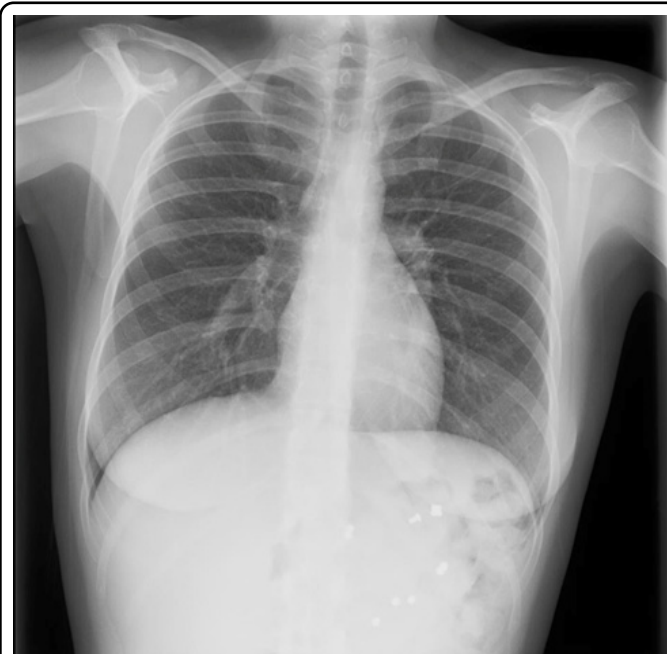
Chest x-ray that rules out pneumoperitoneum and also observed foreign bodies in the gastric chamber.
